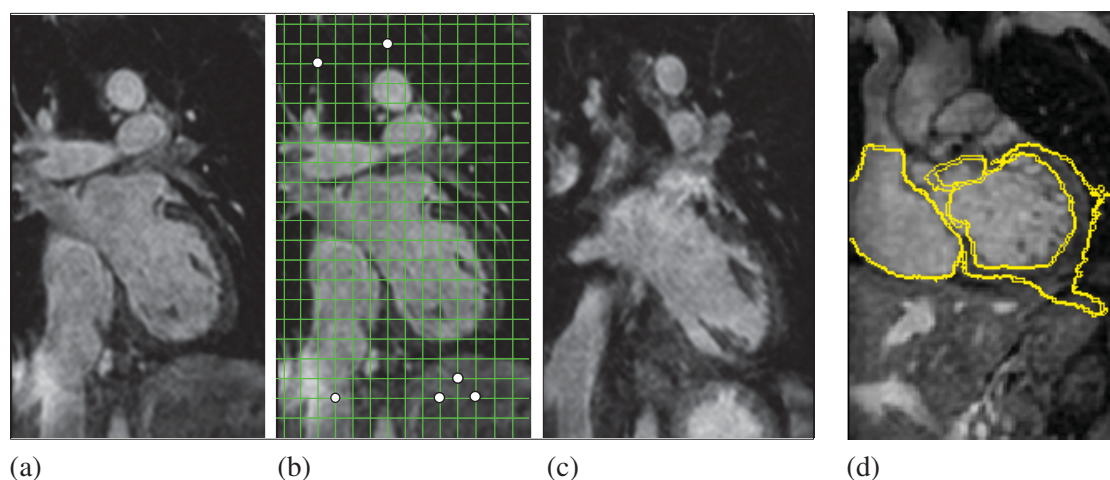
(a): the reference MR image; (b): the FFD mesh on the reference space with unnecessary active control points (white dots); (c): the floating image. (d): an example showing the epicardium leaking in a segmentation using standard FFD registration for the segmentation refinement.
